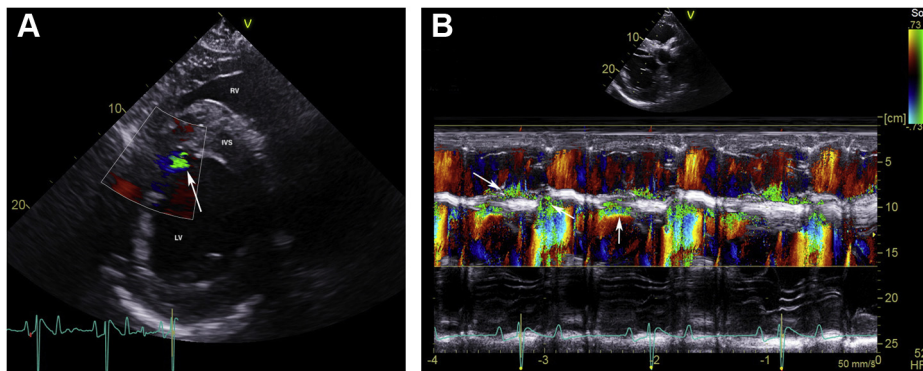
Color flow Doppler (A) and color M-mode echocardiography (B) of the left-to-right shunt through the ACF with subendocardial dissection and a small jet extending into the left ventricle (*arrow*). All images were obtained from the right parasternal window immediately after ACF diagnosis. (A) Color Doppler two-dimensional echocardiogram of the shunt into the left ventricle along the caudal edge of the subendocardial dissection (*arrow*) in the short-axis view of the left ventricle, just below the mitral valve. (B) Color M-mode echocardiogram of the left-to-right shunt through the ACF and turbulent flow in the subendocardial dissection obtained from the short-axis view between the aorta and mitral valve. The *vertical arrow* demonstrates turbulence in the subendocardial dissection, while the *diagonal arrows* represent turbulence from the right sinus of Valsalva into the right ventricle. IVS, interventricular septum; LV, left ventricle; RV, right ventricle.
